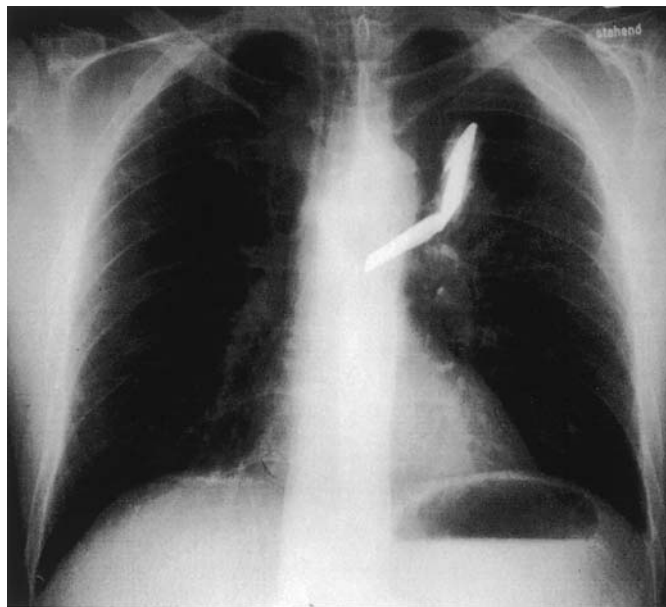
Posteroanterior radiograph of the chest showing the knife blade in the left paravertebral area where the aorta descends.
